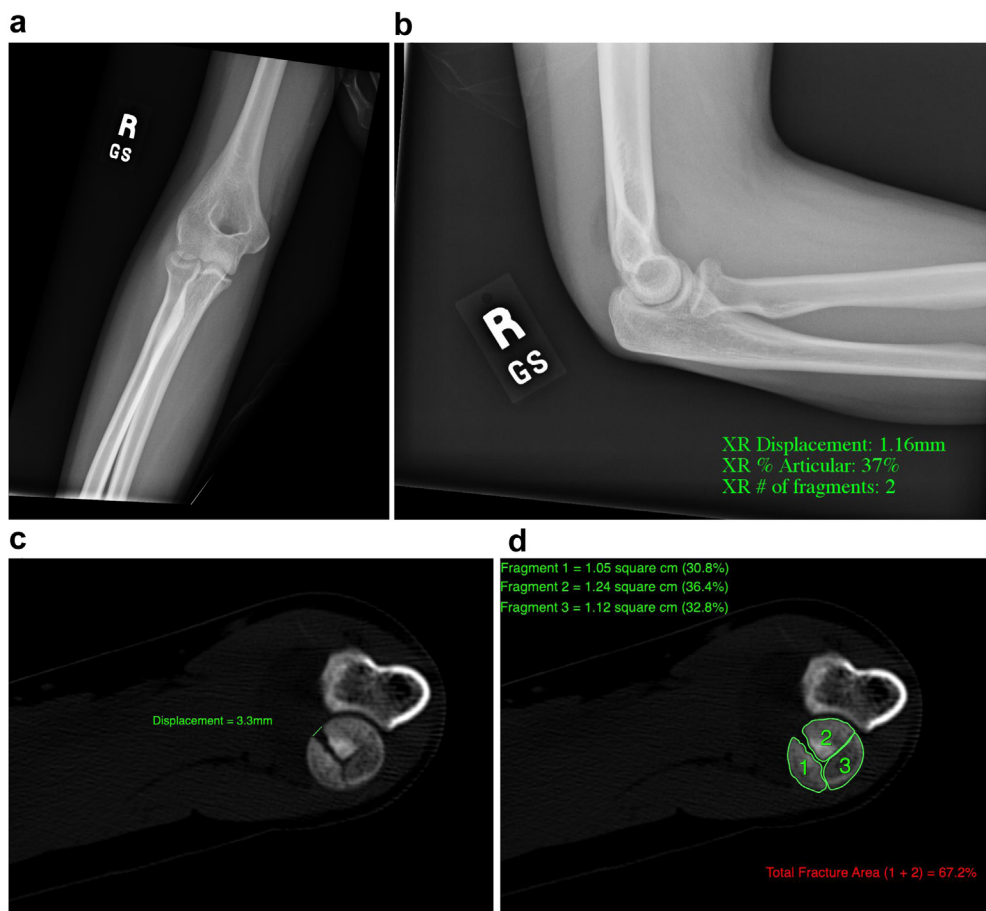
(a-d) A case example of a 31-year-old female who suffered an isolated Mason II radial head fracture. Average measurements among all reviewers are visible in (b). Reference measurements using the reference standard CT imaging are listed in (c) and (d), alongside their representative measurement depictions. For all 3 parameters, radiographic assessment considerably underestimated the severity of the fracture. CT, computed tomography, R, right, XR, x-ray.
